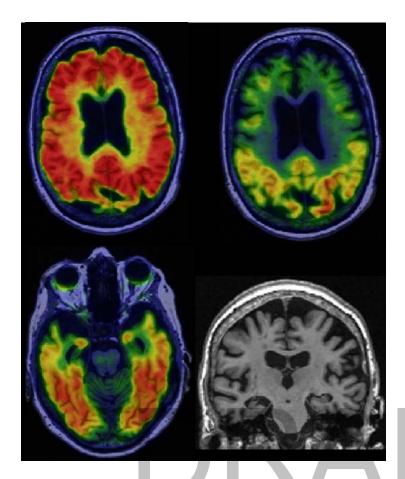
Alzheimer's disease with dementia. 75 yo woman with amnestic multi domain dementia. Participant in the Mayo Alzheimers Disease Research Center. Abnormal amyloid PET (a), tau PET (b,c) and atrophy on MRI (d). Biomarker profile A+T+N+.
